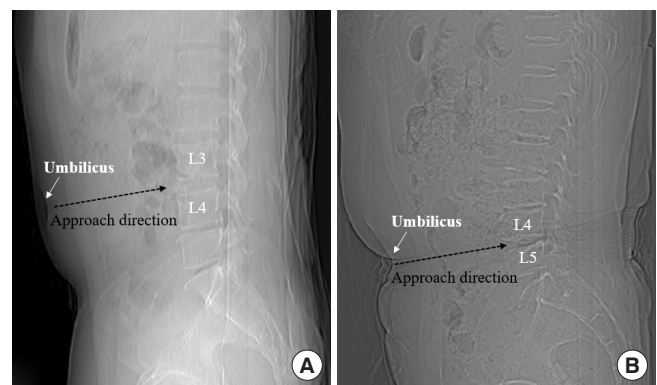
Preoperative sagittal scout computed tomography view used to identify the location of the umbilicus centered on the index levels. These images show examples of cases where the position of the patient's umbilicus is parallel to the L3–4 levels (A) or parallel to the L4–5 levels (B).
